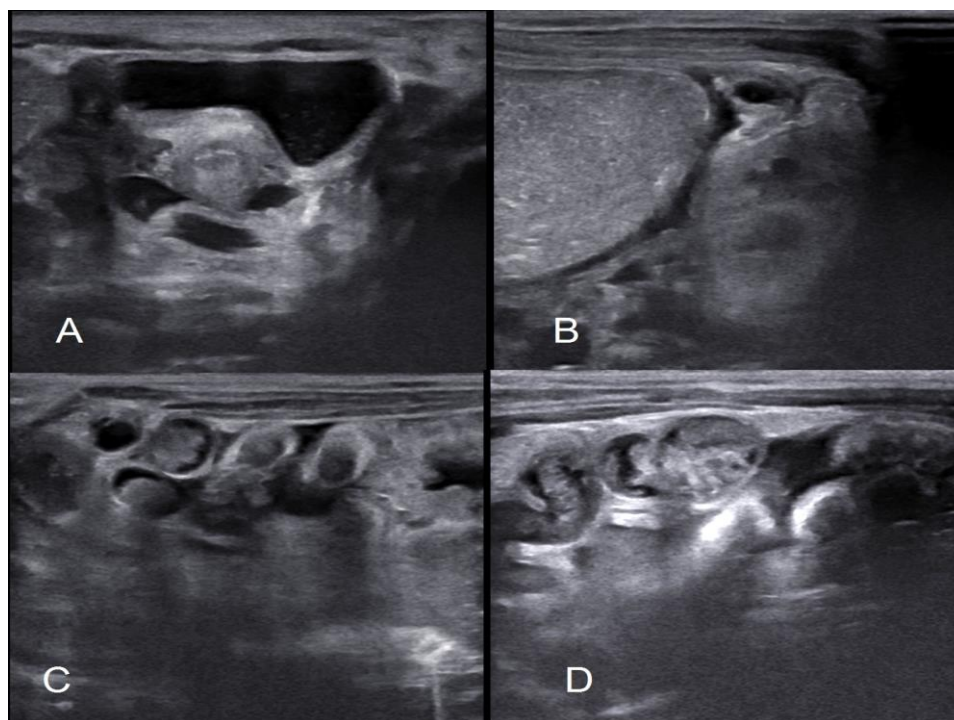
(A-D): The ultrasonographic findings during hydrostatic treatment of meconium ileus; A) Dilatation of descending colon with the arrival of the solution to it. B and C). Coating and detachment of meconium plaques from bowel wall and floating of them. D) The arrival of solution to around of liquated meconium in distended proximal bowel loop.
